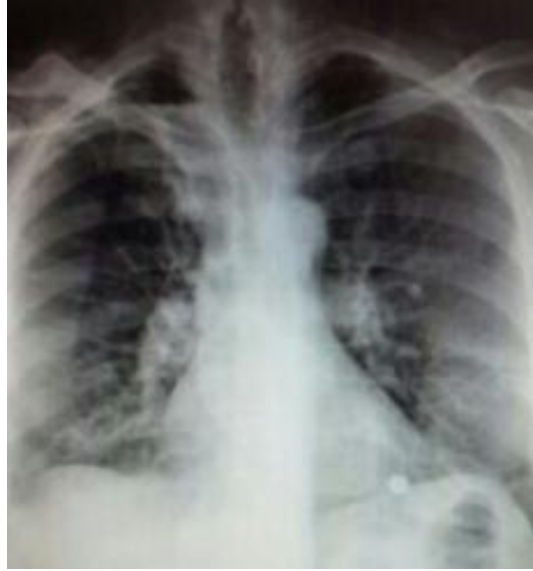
Control chest radiography
